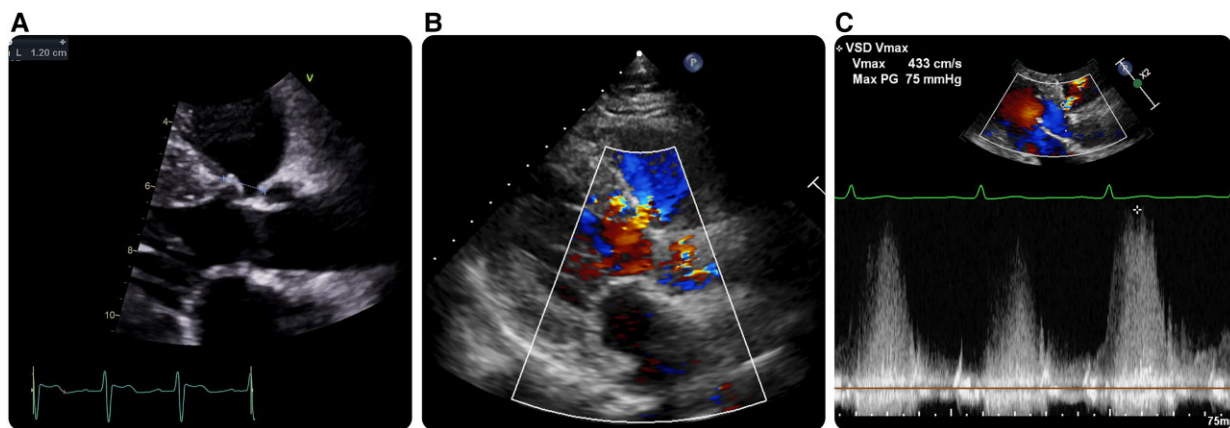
(A) Ventricular septal defect measuring 1.20 cm from parasternal long axis view. (B) Colour Doppler through ventricular septal defect. (C) Continuous wave Doppler through ventricular septal defect.
